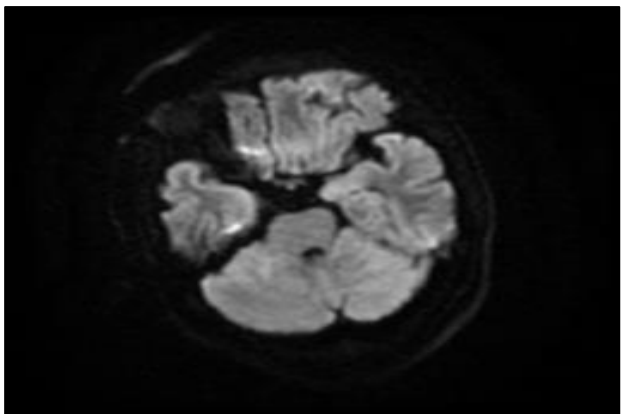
MRI brain showing complete resolution of all previous lesions.
